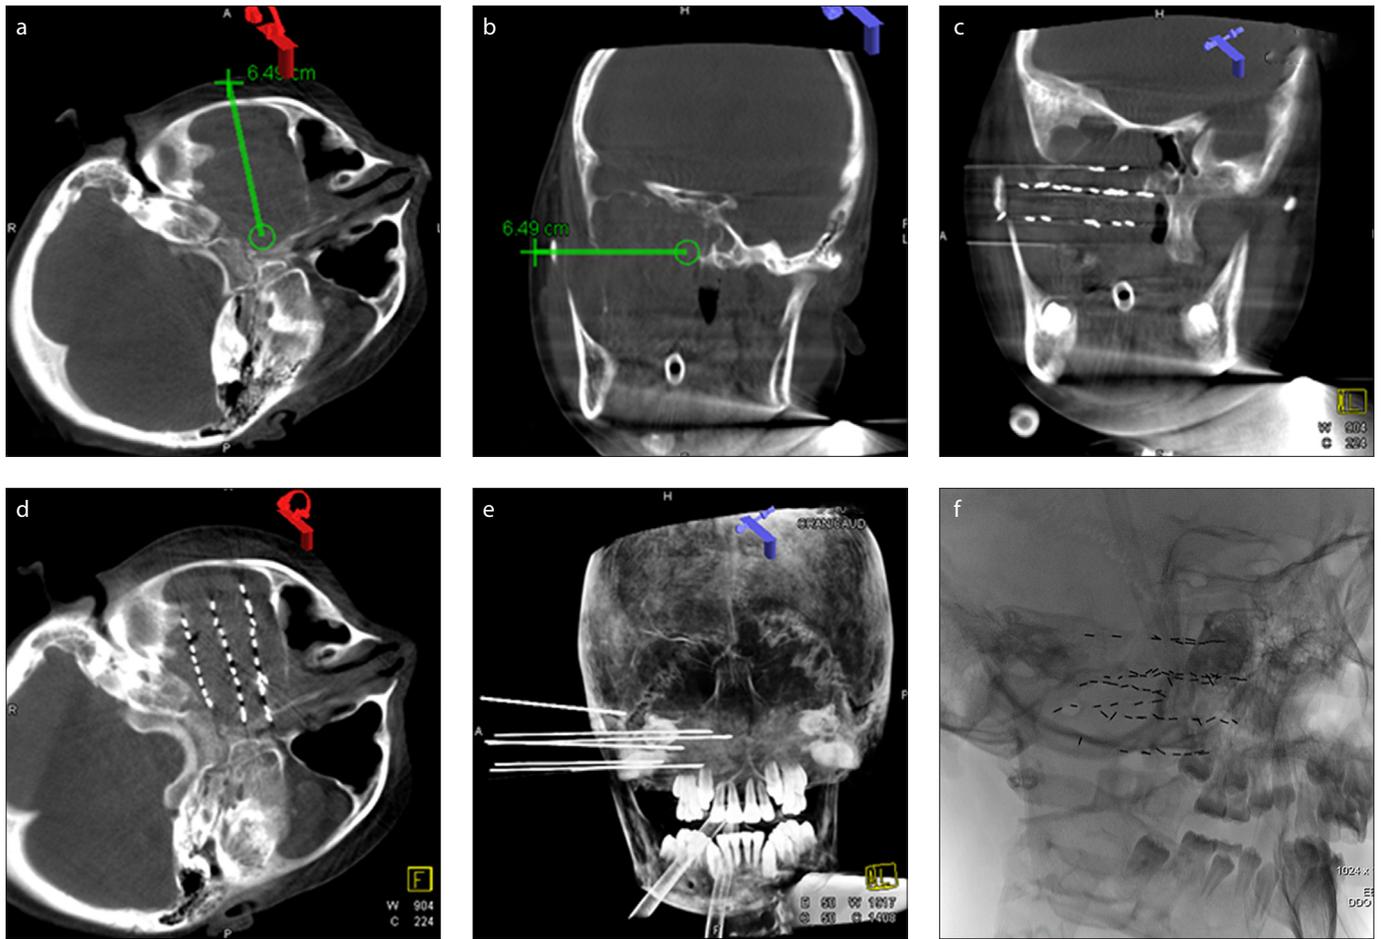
a–f. Axial (a) and sagittal (b) DynaCT images show a 54-year-old male lung cancer patient presenting with skull metastasis. The treatment was carried out under general anesthesia. After brachytherapy treatment planning system (TPS) was used to formulate the treatment plan, implantation of the ^{125}I seeds (c–e) was completed based on the brachytherapy path provided by DynaCT. Digital radiography (f) image confirms that the ^{125}I seeds have been successfully placed at the specified location. The visual analogue scale (VAS) pain scores of patients before and 12 hours after ^{125}I seed brachytherapy were 8 points and 3 points respectively, and the pain was significantly relieved.
